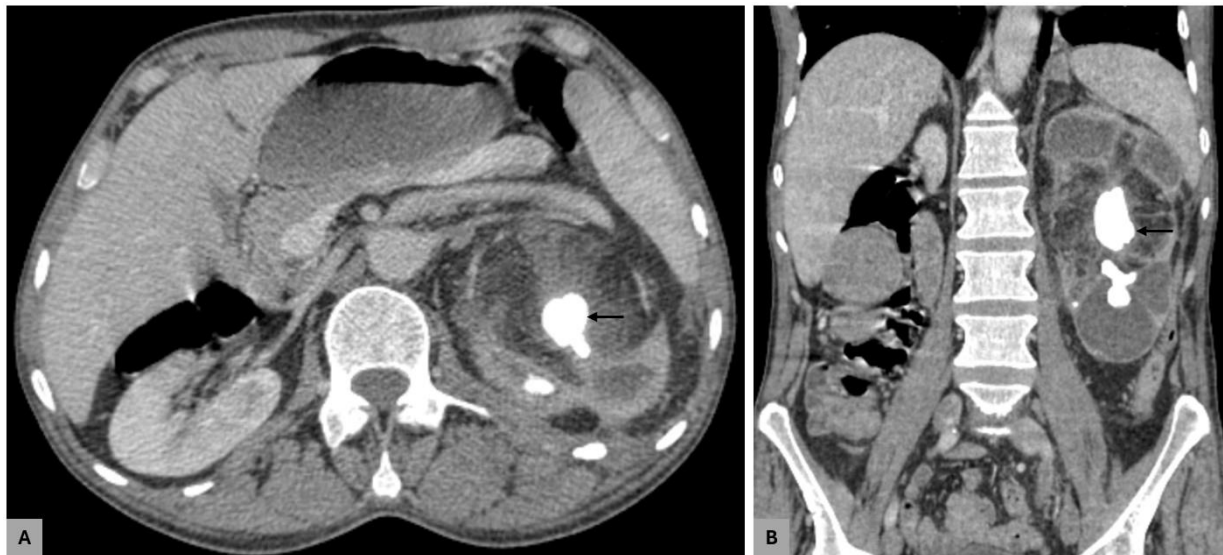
Contrast-enhanced computed tomography of the abdomen at initial presentation demonstrating an enlarged left kidney with marked calyceal dilation and a central staghorn calculus occupying the renal pelvis (black arrow).
